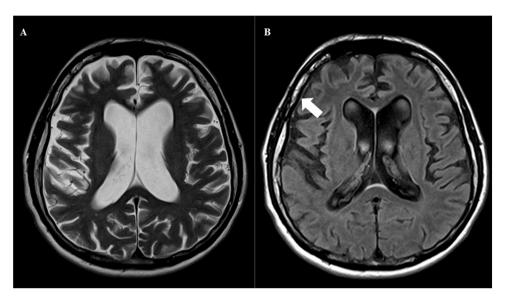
MRI axial T2-weighted (A) and FLAIR (B) images demonstrating diffuse atrophy, bilateral lamellar subdural hygromas, and dural thickening (arrow).
